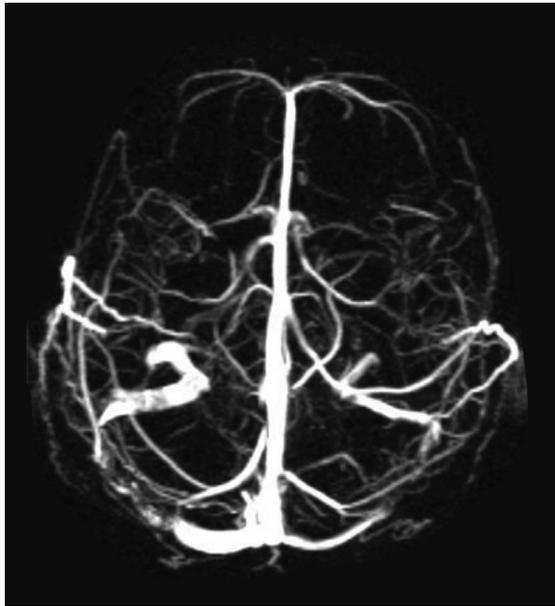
The appearance of local occlusion in bilateral transverse sinuses in magnetic resonance imaging venography
